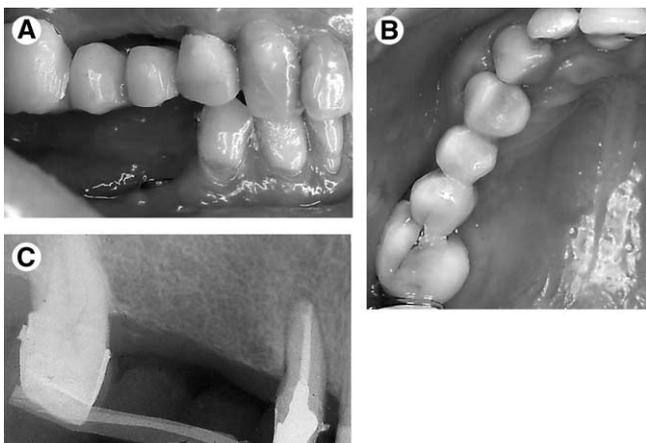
Class II malocclusion and missing upper right 2nd premolar and 1st molar with right lateral incisor rotated. (A) Right buccal. (B) Maxillary occlusal. (C) Bitewing x-ray.
